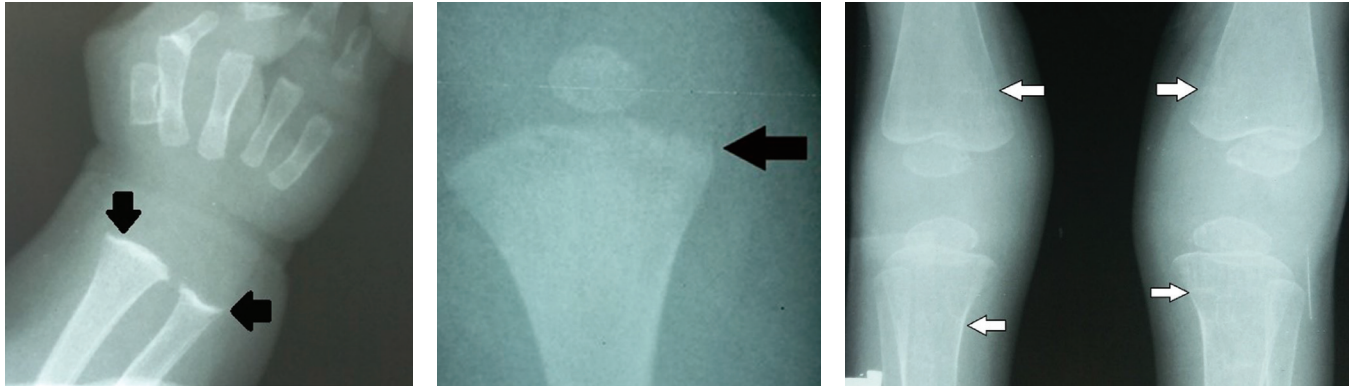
Radiographic findings. (A) 2-month-old male with concave and frayed metaphyseal margins of the radius and ulna (black arrows). (B) Six-week-old female with partial lucency and disappearance of the smooth metaphyseal margins of the femur (black arrow). (C) Incidental findings of bilateral stress fractures in the femur and tibia (white arrows) in a 1-year-old male.
